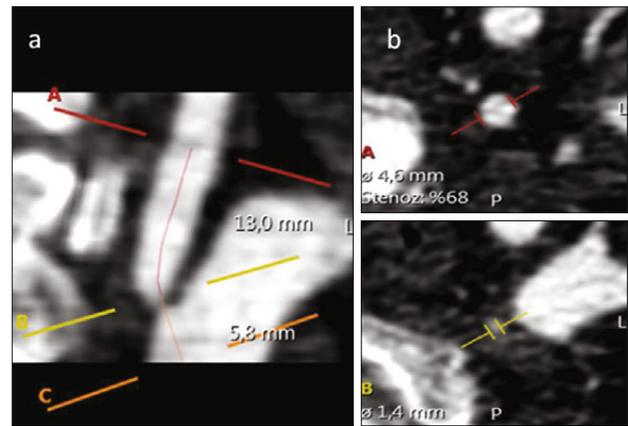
a) At the level of left Vertebral Artery (VA) preforaminal segment ostium, CTA shows the significant stenosis at level B, b) the stenosis rate was calculated 68 % compared with normal VA lumen at level A.
